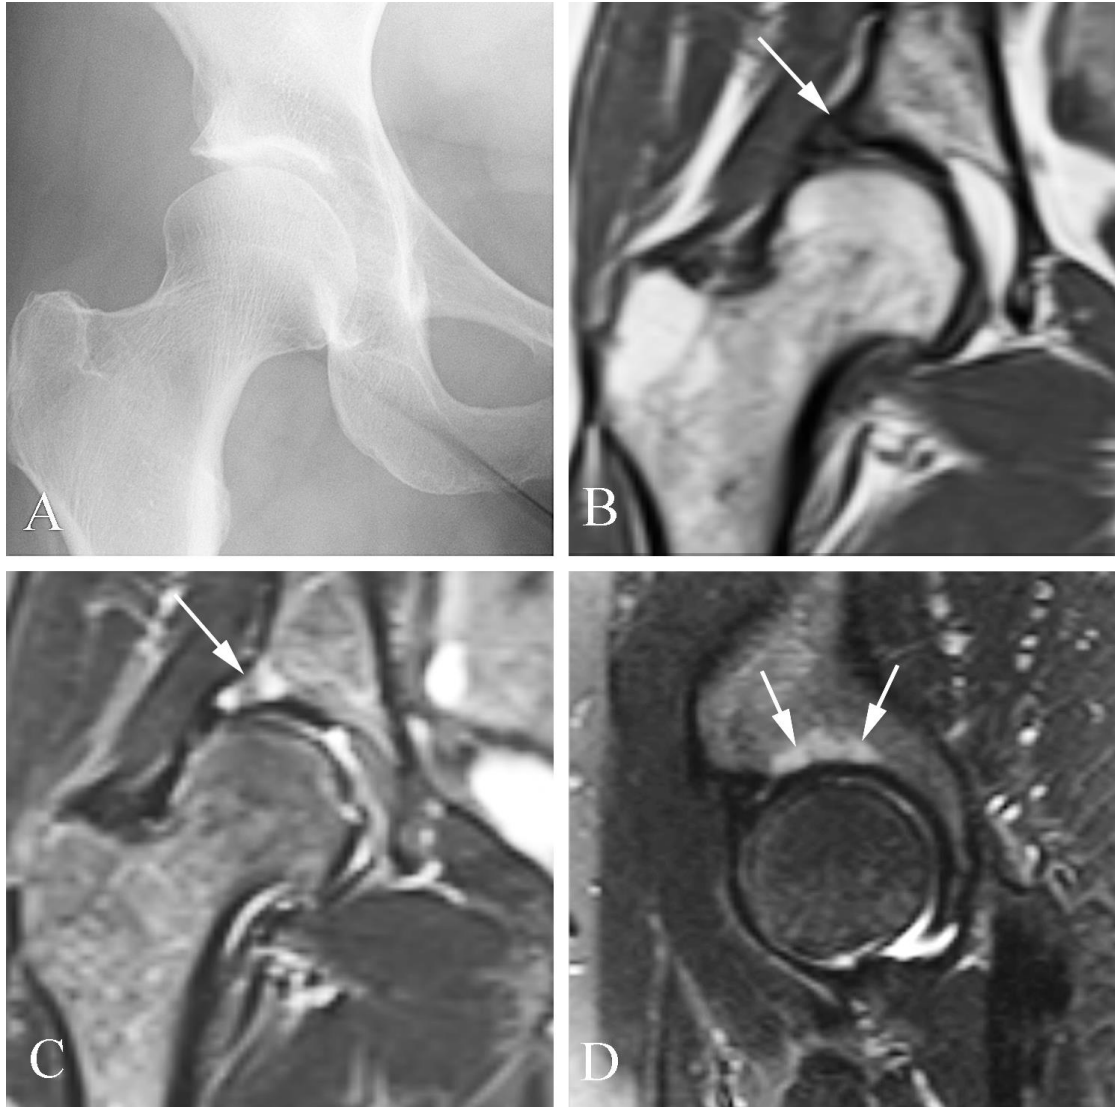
Early degenerative change seen on an MR study in a 50 year old woman with chronic hip pain. A. AP plain film of the hip shows no significant joint space narrowing, subchondral sclerosis, osteophytic spurring, or subchondral cyst formation. B. Coronal T1 weighted image demonstrates abnormal decreased signal intensity in the acetabulum (arrow). C. Coronal fat-suppressed proton density image demonstrates abnormal increased signal intensity in the acetabulum. D. Sagittal STIR image confirms abnormal signal intensity in the acetabulum.
